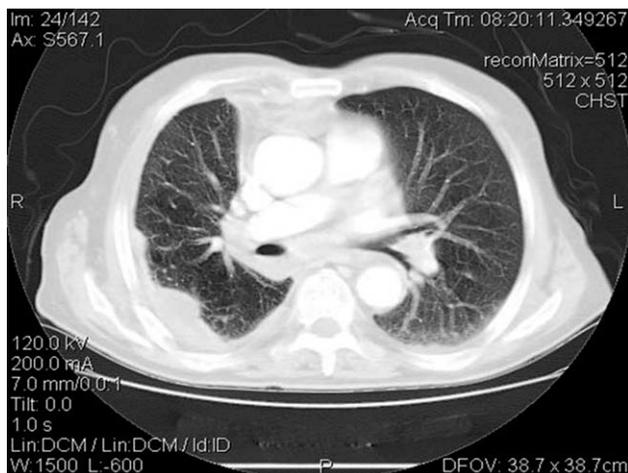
CT of the thorax after thoracocentesis.
